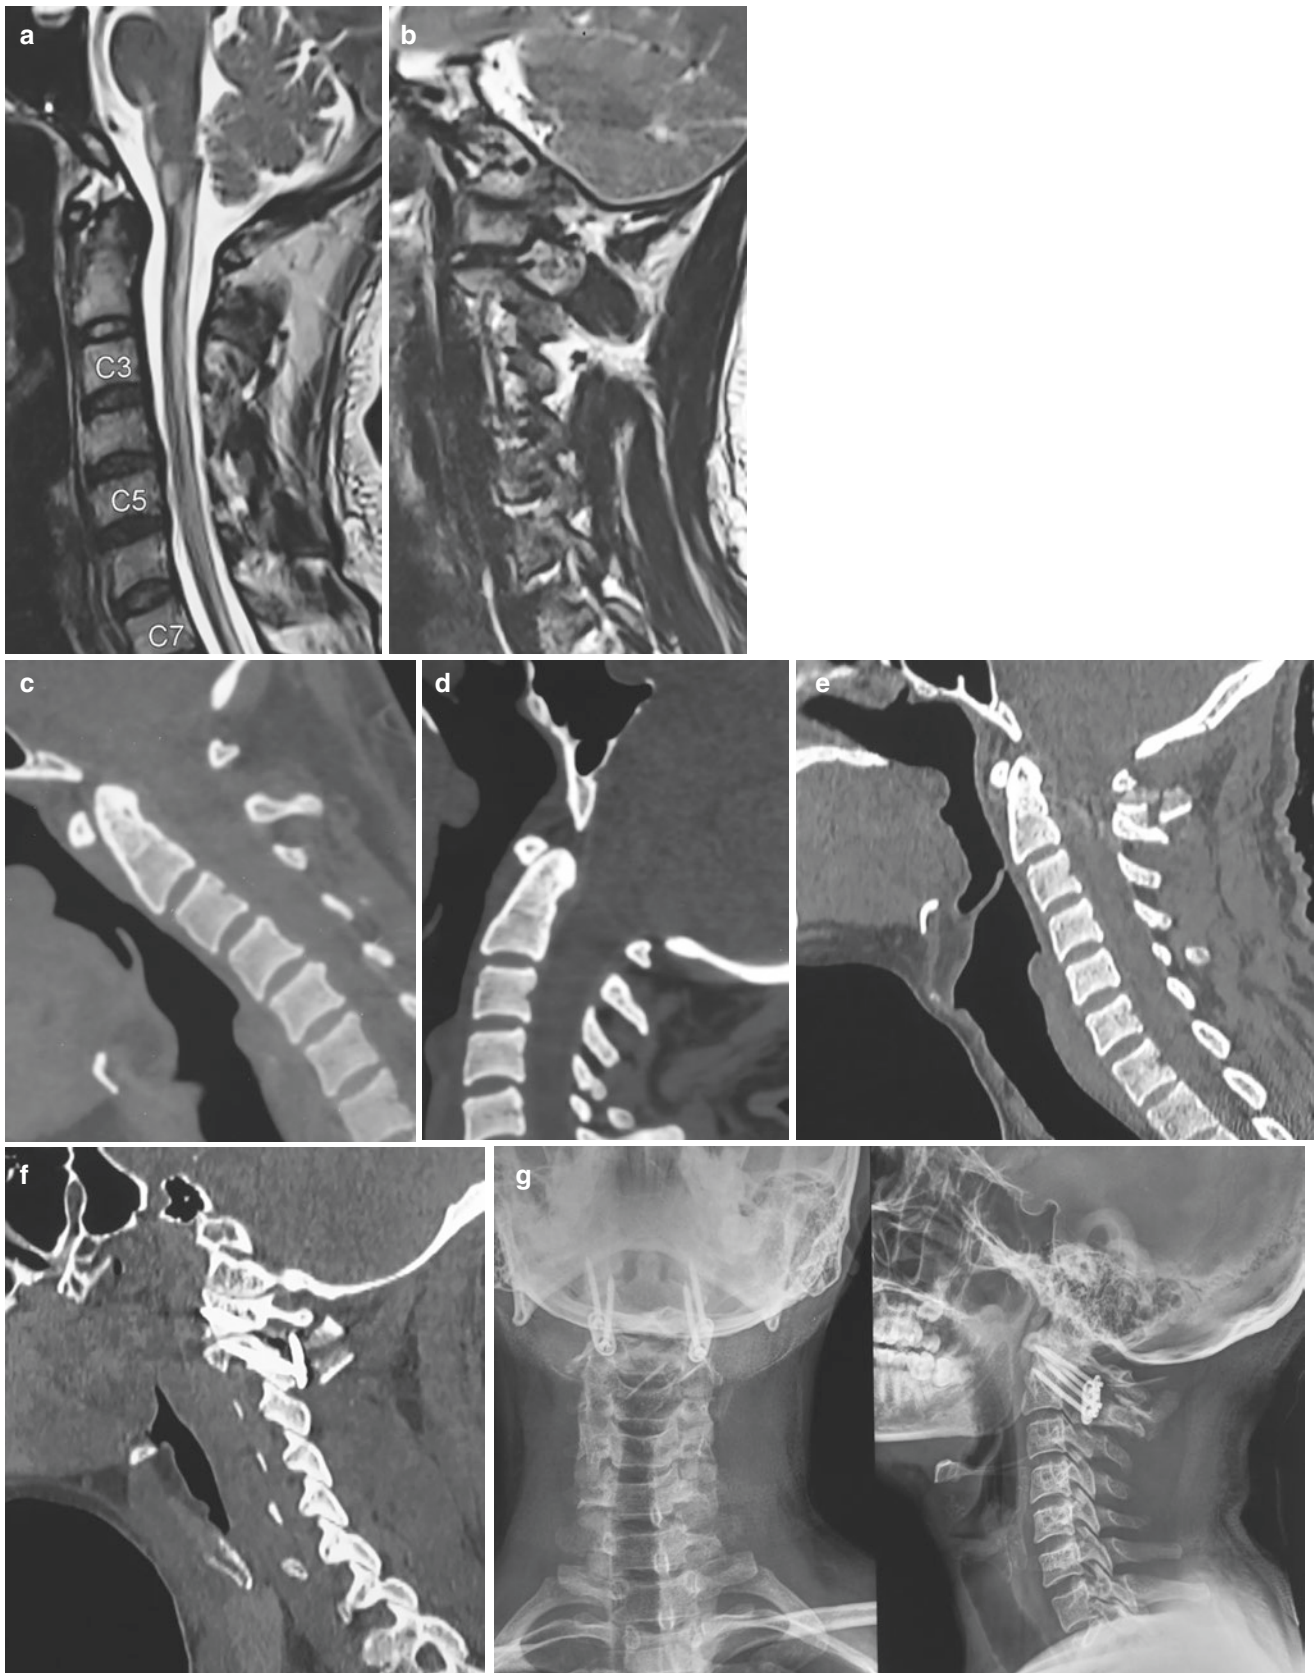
Images of a 37-year-old male patient. (a) T2-weighted MRI of the cervical spine showing hyperintense signal abnormality extending from the craniovertebral junction to the C3-C4 level. (b) Sagittal cut of MRI through the facets showing type 2 facet joint instability. (c) Sagittal CT scan of the craniovertebral junction in flexion showing mild vertical
